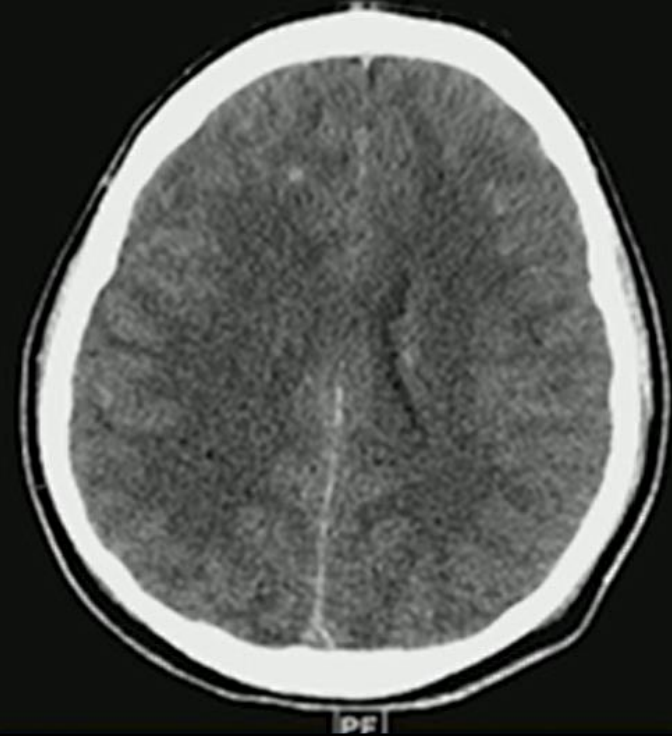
The CT Appearance of Diffuse Axonal Injury. Noncontrast CT images show a punctate high attenuation focus (*arrowhead*) within the left frontal subcortical white matter (A) and mixed linear and amorphous high attenuation (*arrowhead*) within the left splenium of the corpus callosum (B), consistent with hemorrhagic diffuse axonal injury.
